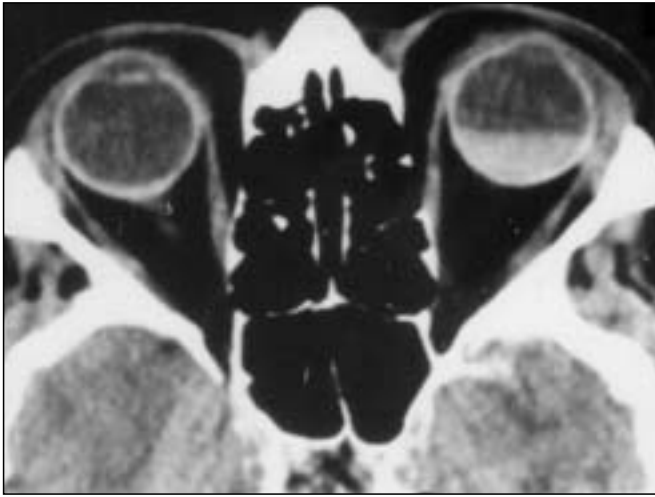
A head CT scan of the patient after receiving systemic t-PA revealed a dense vitreous hemorrhage in the left eye. Note the shallow anterior chamber in the left eye compared to the normal right eye.
